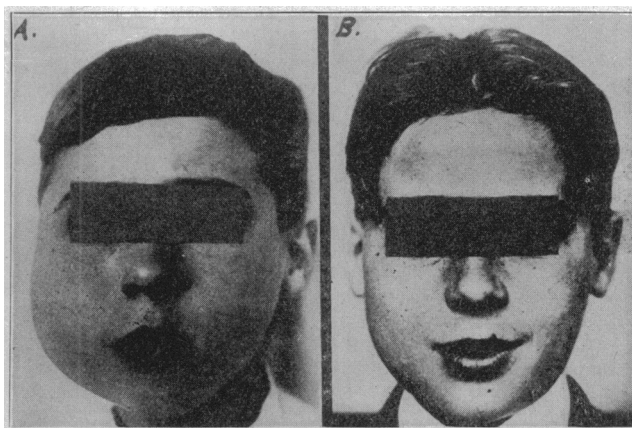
(Case 16).—(A) Sarcoma involving all of the right lower jaw, part of the upper jaw, together with the soft tissues, Jan. 8, 1916, treated by deep roentgenotherapy (A); B, same patient apparently free from disease, May 8, 1916.
